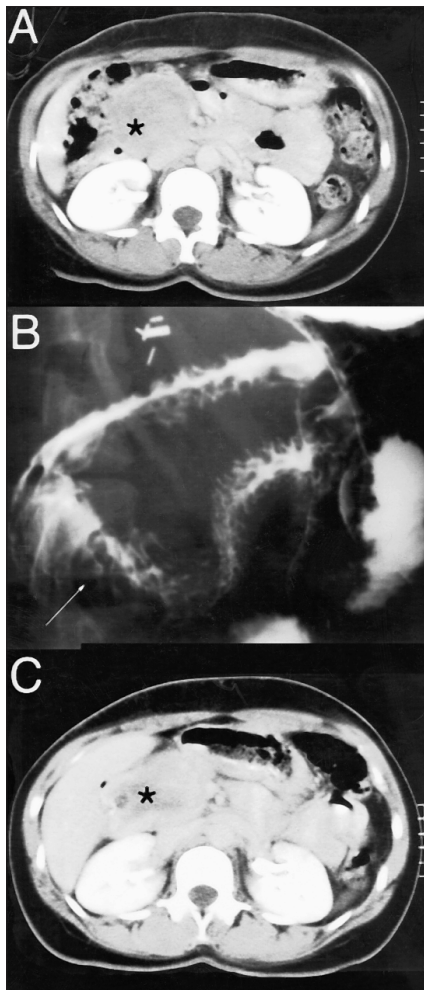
CT scan of the abdomen (A) shows a well-defined mass (\*) localized near the second and third portions of the duodenum. Upper gastrointestinal series (B) shows widening of the duodenum. A follow-up CT scan at 1 year (C) shows a slight increase in the size of the mass with partial loss of tumour contours.
